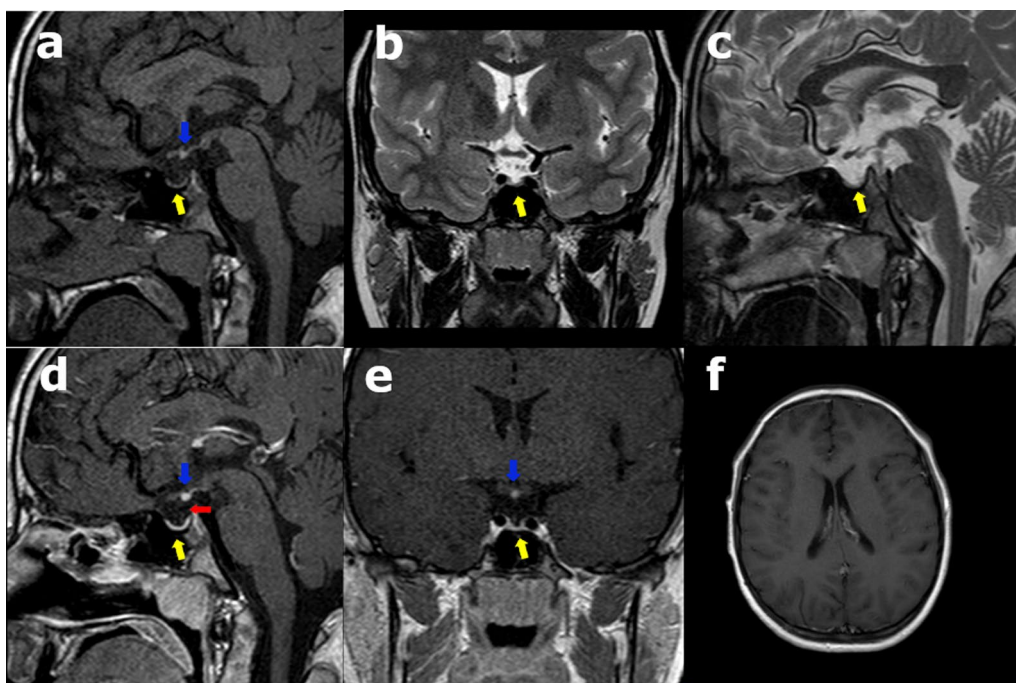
MRI findings in a 17-year-old male patient presenting with short stature, delayed puberty, and hypopituitarism. a Sagittal non-contrast T1W image of the pituitary gland showing small anterior pituitary (yellow arrow), absent pituitary stalk, and ectopic posterior pituitary (blue arrow) seen as hyperintense focus posterior to the optic chiasm. b Coronal T2W image of the pituitary gland showing small anterior pituitary (yellow arrow) with absent pituitary stalk. c Sagittal T2W image of the pituitary gland showing small anterior pituitary (yellow arrow) with absent pituitary stalk. d Sagittal post-contrast (IV Gd) T1W image of the pituitary gland showing homogenous enhancement of the hypoplastic anterior pituitary (yellow arrow) and homogenous enhancement of the ectopic posterior pituitary gland (blue arrow) and absent pituitary stalk (red arrow). e Coronal T1W post-contrast (IV Gd) of the pituitary gland showing homogenous enhancement of the hypoplastic anterior pituitary (yellow arrow) and homogenous enhancement of the ectopic posterior pituitary (blue arrow). f Axial post-contrast (IV Gd) T1W brain MRI showing normal septum pellucidum and normal brain midline structures, no hydrocephalus, normal corpus callosum
